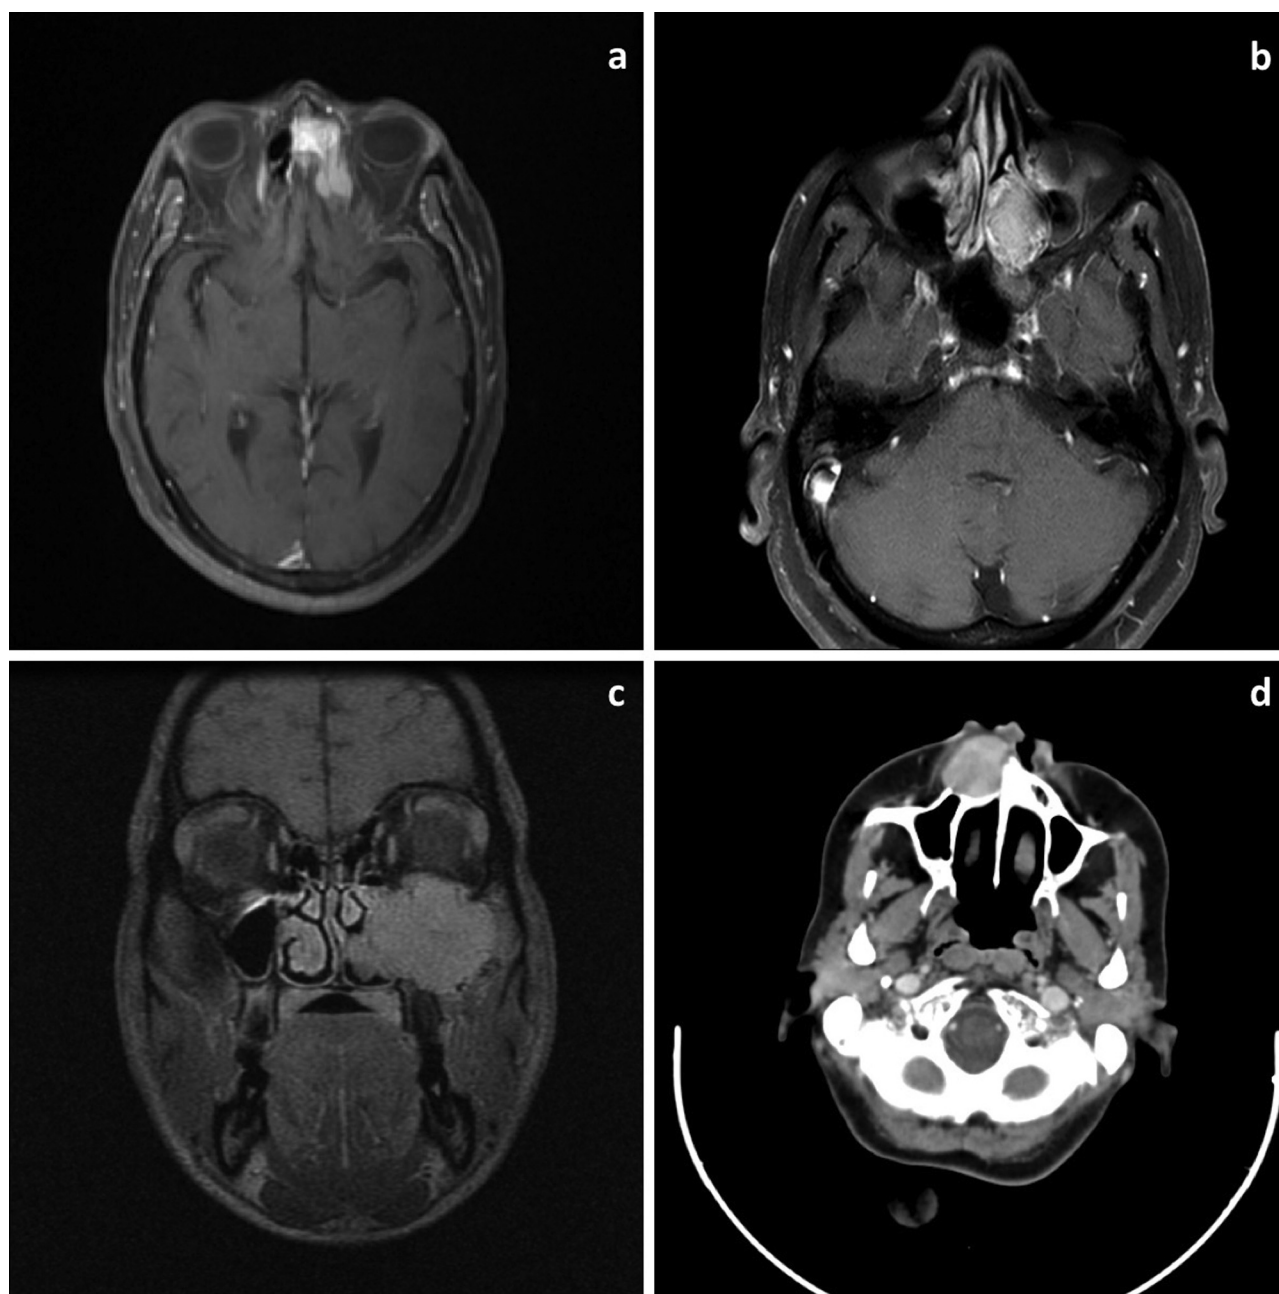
Axial post-contrast T1W MR images from cases 1 (a) and 3 (b) show enhancing lesions in left ethmoid air cells; coronal T1W MR image from case 5 shows a large, expansile mass filling the left maxillary sinus and extending into the nasal cavity (c); Axial CECT from case 6 shows a moderately enhancing mass in relation to the right upper alveolus, causing bony erosion (d).
